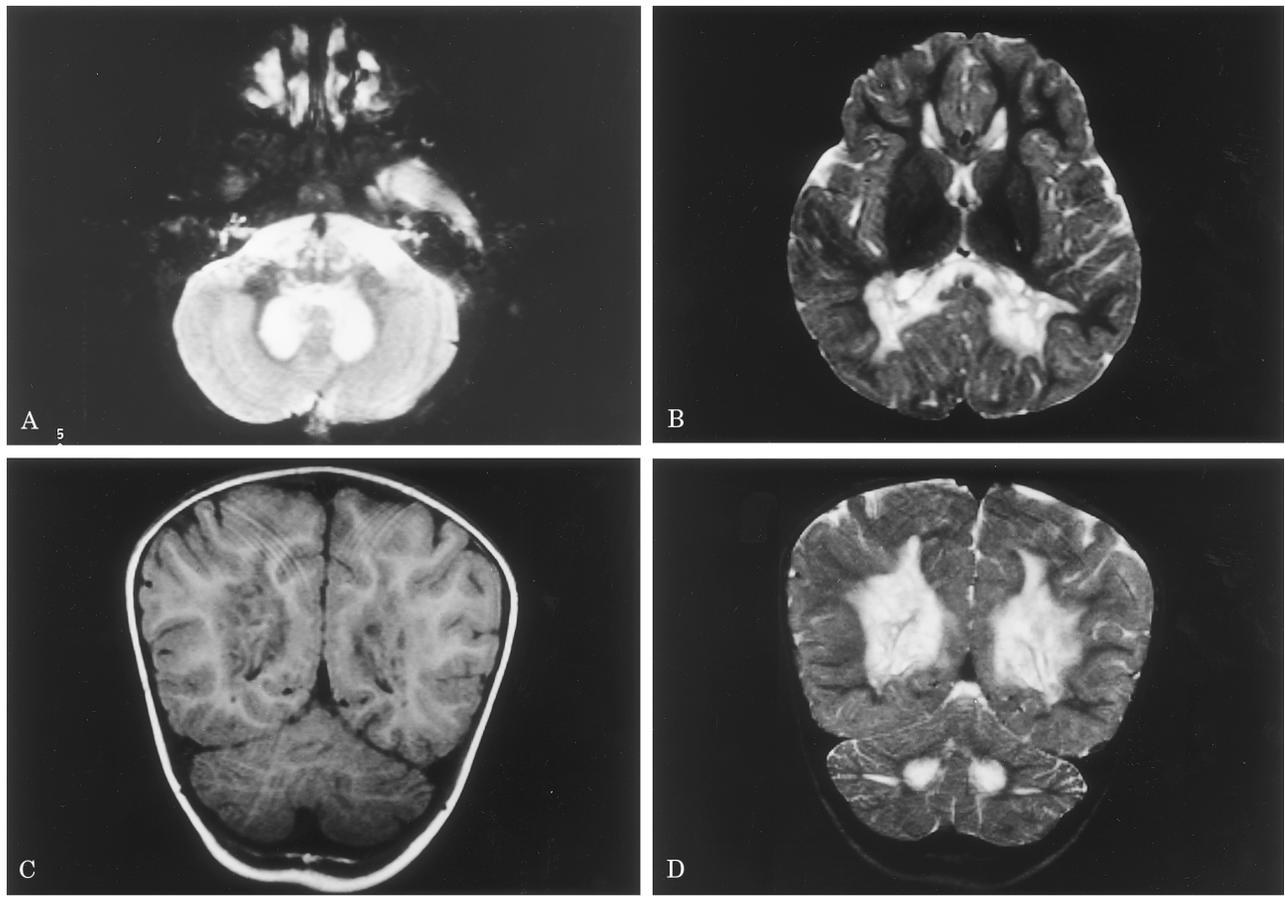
Magnetic resonance images of the patient's brain at age 2 years 5 months. (A) Axial T2-weighted image demonstrating abnormal high signal in the cerebellar white matter. (B) Axial T2-weighted image demonstrating abnormal high signal in the splenium and internal capsule. No lesions are visible in the basal ganglia. (C) Coronal T1-weighted image demonstrating cystlike lesions in the white matter. (D) Cystlike lesions in the white matter are also seen in this coronal T2-weighted image, which also demonstrates abnormal high signal in the cerebral and cerebellar white matter.
